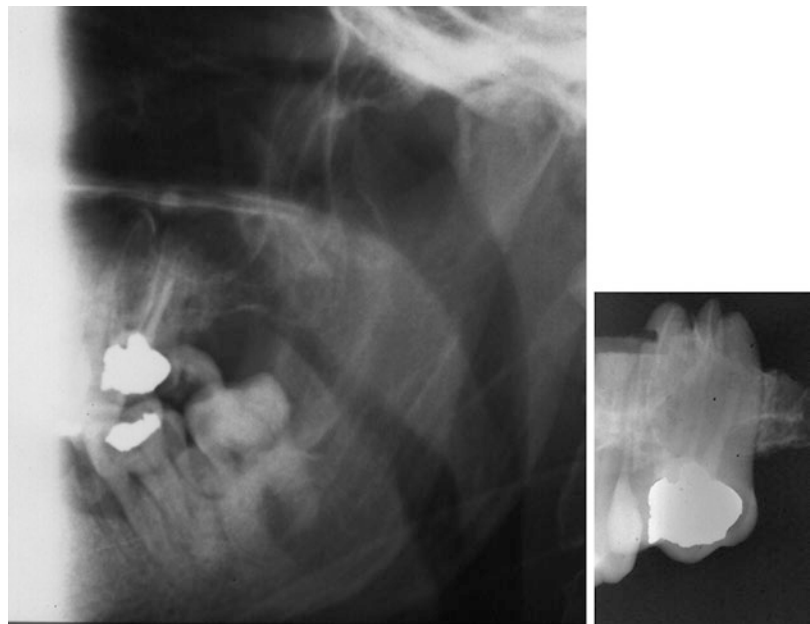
On the left, an ante-mortem portion of an OPG showing a wisdom tooth; on the right the post-mortem periapical radiograph performed for identification purposes
